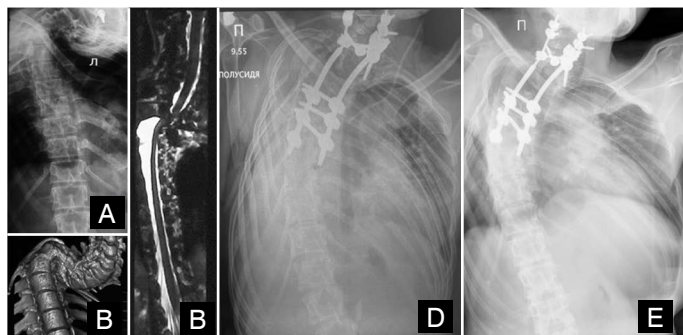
Preoperative and Postoperative Imaging: Case 2. (a) X-ray of the spine revealing scoliosis; (b) 3D CT reconstruction of the upper thoracic spine depicting features of dystrophic scoliosis; (c) MR slice through the apex of the deformity, displaying dural ectasia and stenosis; (d) Postoperative chest X-ray 4 days after scoliosis surgery, revealing a tense right-sided hemothorax; (e) Chest and spine X-ray captured eight years after surgery.
